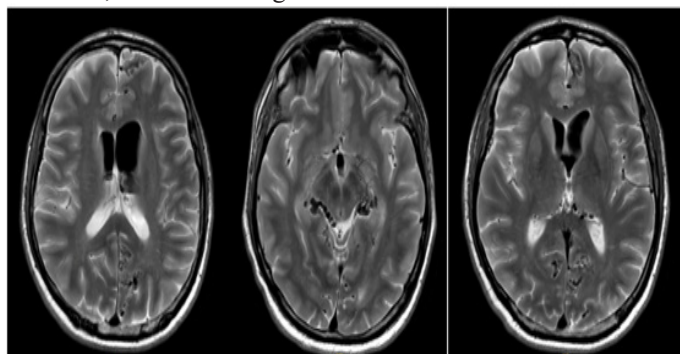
Widespread pneumocephalus observed in the follow-up MRI.
